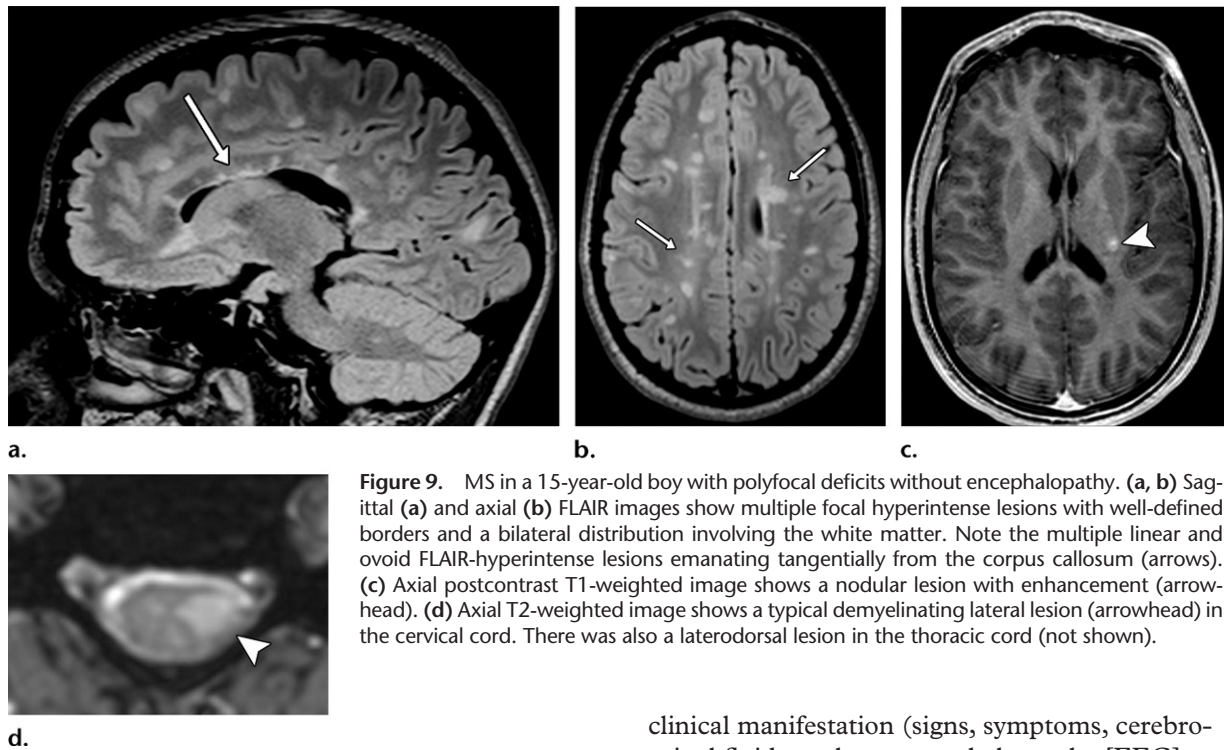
MS in a 15-year-old boy with polyfocal deficits without encephalopathy. (a, b) Sagittal (a) and axial (b) FLAIR images show multiple focal hyperintense lesions with well-defined borders and a bilateral distribution involving the white matter. Note the multiple linear and ovoid FLAIR-hyperintense lesions emanating tangentially from the corpus callosum (arrows). (c) Axial postcontrast T1-weighted image shows a nodular lesion with enhancement (arrowhead). (d) Axial T2-weighted image shows a typical demyelinating lateral lesion (arrowhead) in the cervical cord. There was also a laterodorsal lesion in the thoracic cord (not shown).
